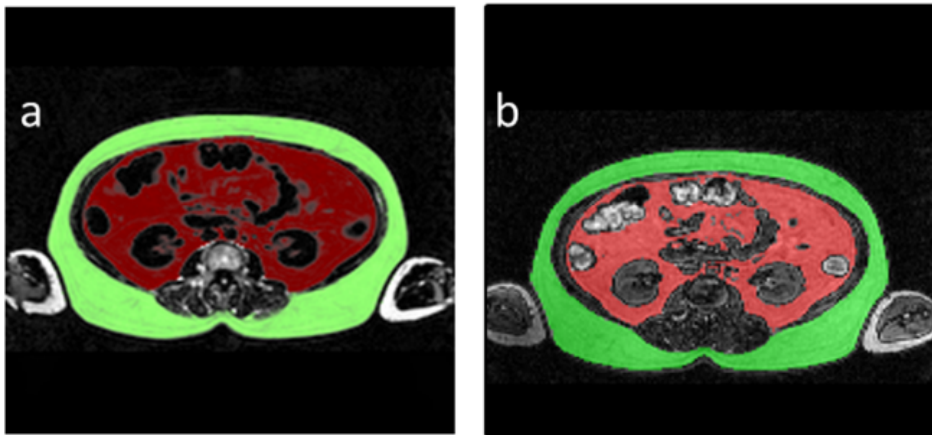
MR images from typical volunteer. (a) The calibrated fat image with intra-abdominal and subcutaneous segmentations made by the AMRA™ Profiler overlaid in red and green respectively. (b) The approximately corresponding transverse slice from the same subject analysed by sliceOmatic. In this example both images were acquired with the volunteer positioned in a supine position to make the images more readily comparable
